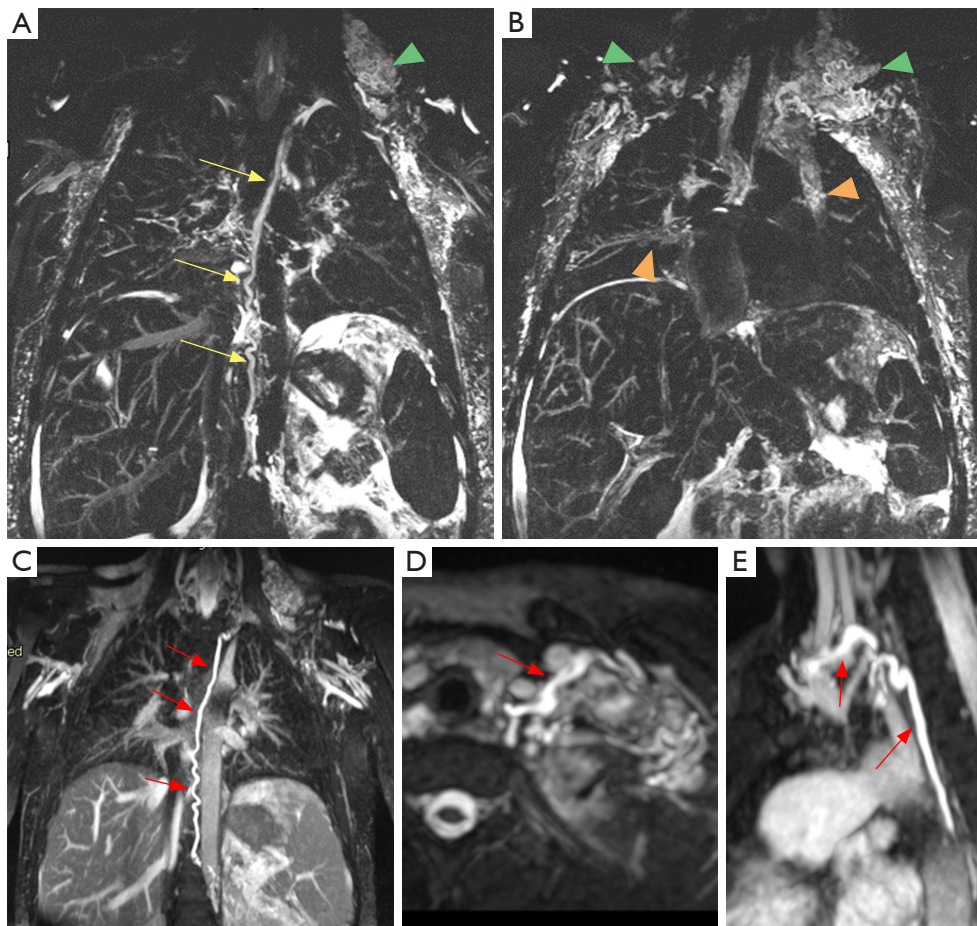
Adult female with protein losing enteropathy in Fontan circulation. High T2-weighted imaging (A,B) shows a dilated thoracic duct measuring 4 mm (A, yellow arrows) and abnormal lymphatic tissue bilaterally in the supraclavicular region (green arrowheads) extending into the lungs (orange arrowheads). Improved visualization of the thoracic duct (red arrows) can be reached with 3D steady state free precession sequence (C-E). The thoracic duct can be followed throughout its entire course in the upper chest with no obvious stenosis seen (D,E). The patient was treated with sildenafil and heart failure medication including diuretics.
